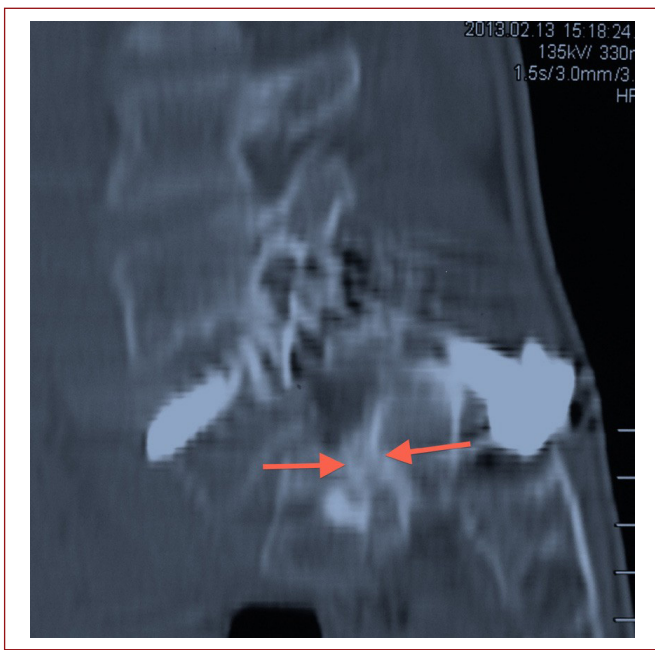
Sagittal CT shows solid bone fusion, the red arrows show the fusion area of the fibular allograft strut bone.
